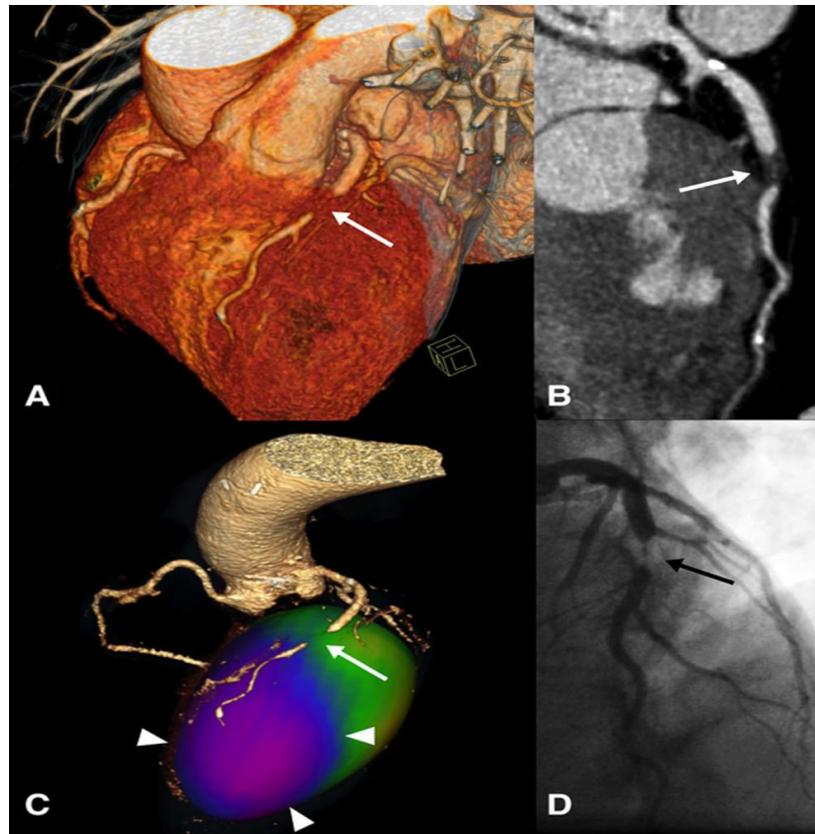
Coronary artery Computed Tomography scan, showing stenosis caused by non-calcified atheromatous plaque in the mid-left anterior descending coronary artery.
